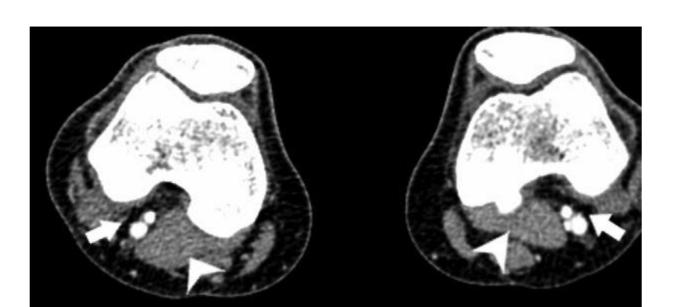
Bilateral Lower Extremity CTA image demonstrating hypertrophy of the medial gastrocnemius muscle bilaterally (arrowheads) leading to mild medial displacement and narrowing of the popliteal arteries bilaterally (arrows)
